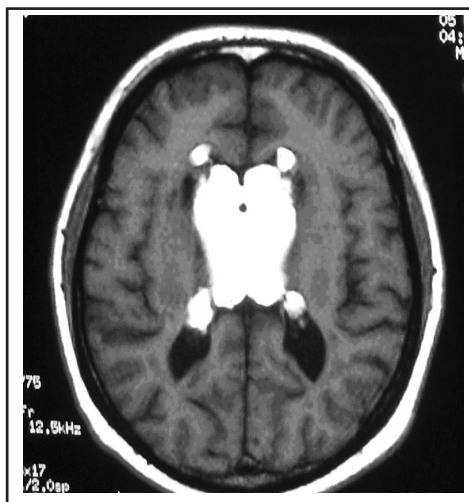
A MRI brain demonstrated a homogenous intraventricular lesion situated mainly over the both frontal horn and body of lateral ventricles.
